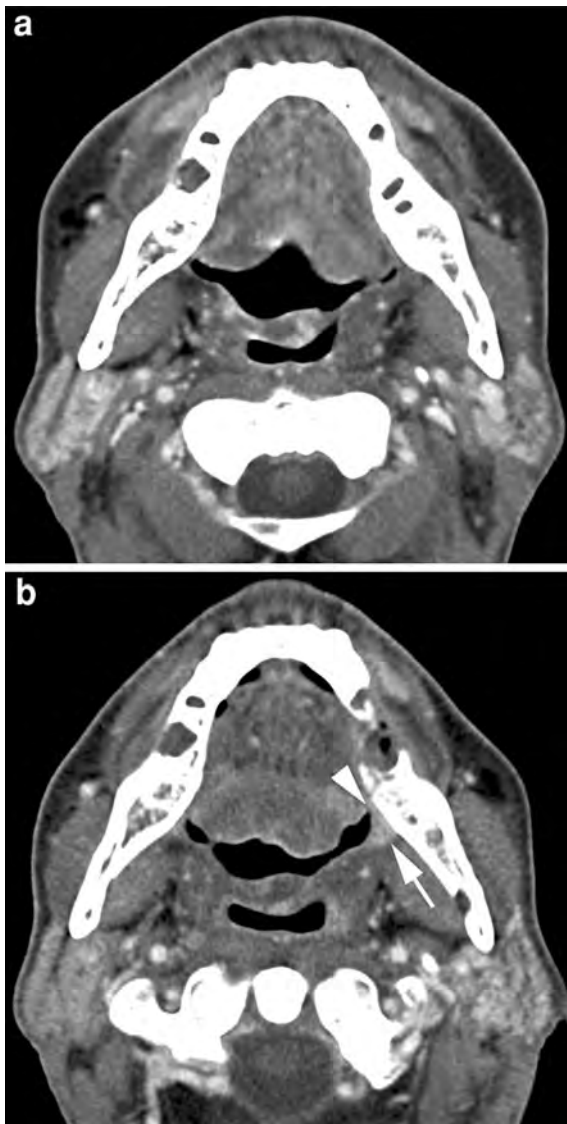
a Axial contrast-enhanced CT image, obtained 4 months after completion of radiotherapy for a T2N1 oropharyngeal cancer. Expected changes after radiotherapy are seen, no evidence for local disease. b. Because of left sided odynophagia and otalgia, a new CT study was obtained 2 months later. Slight soft tissue thickening and increased enhancement is seen in the left anterior tonsillar pillar (*arrow*) extending into glossotonsillar sulcus (*arrowhead*) (compare with A). Clinically, this abnormality corresponded to a small granulomatous lesion. Biopsy revealed squamous cell cancer
